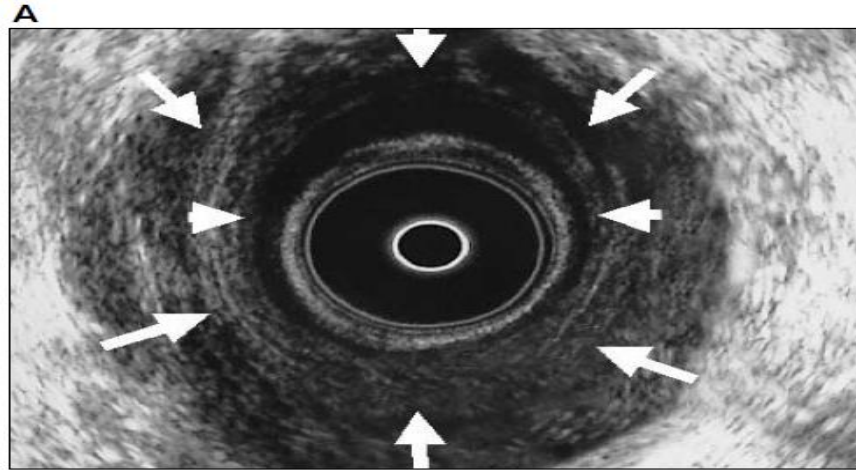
3D-endorectal ultrasound. The anal canal is divided into three levels of assessment in the axial plane, defined by the following landmarks: (A) upper level: puborectalis muscle (PR); (B) middle level: internal (IAS) and external anal sphincter (EAS); (C) lower level: external anal sphincter.
